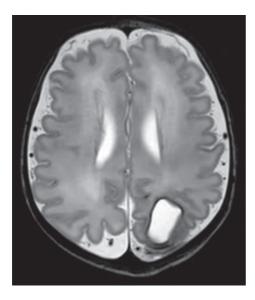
Neonatal cerebral MRI showing a large porencephalic cyst in the left occipital lobe. The cyst is a remnant of a large antenatal ICH, detected at 27 weeks' of gestation.
